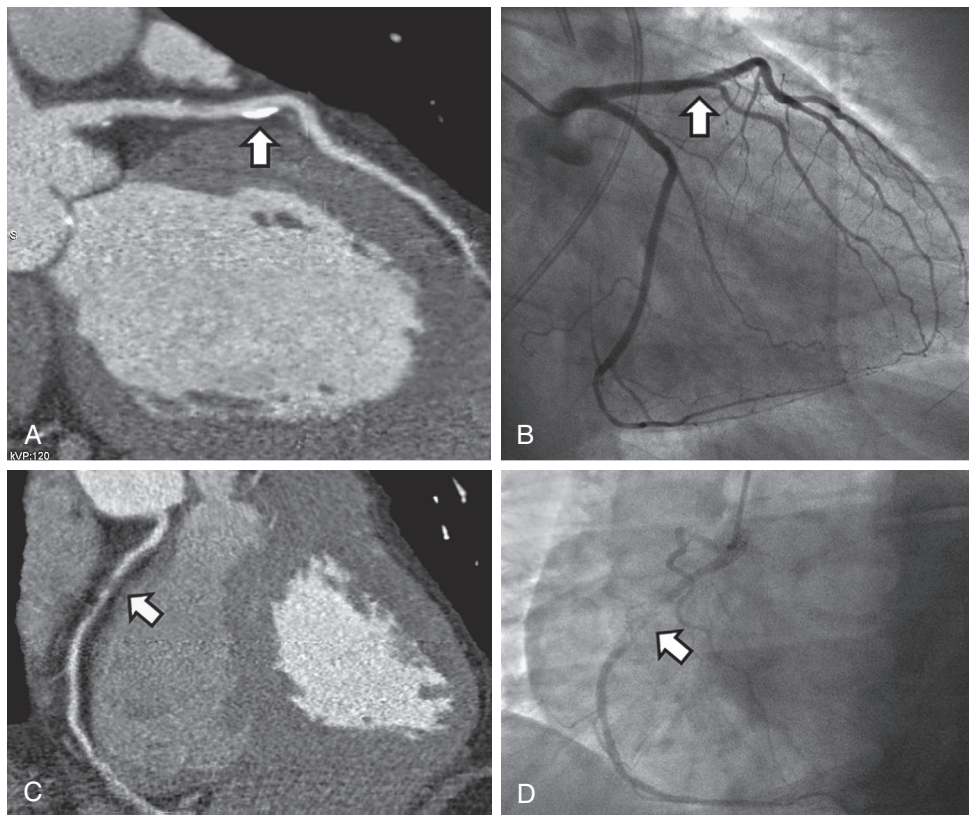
■ Coronary artery disease. A, Curved multiplanar reformation cardiovascular computed tomographic image of the left anterior descending coronary artery shows a calcified plaque (arrow) without stenosis. B, Invasive radiographic angiography confirmed the absence of stenosis, with the plaque present as a subtle indentation of the lumen (arrow). C, Curved multiplanar reformation cardiovascular computed tomographic image of the right coronary artery showing a noncalcified plaque with severe stenosis (arrow). D, Invasive radiographic angiography confirmed the presence of severe stenosis (arrow).
